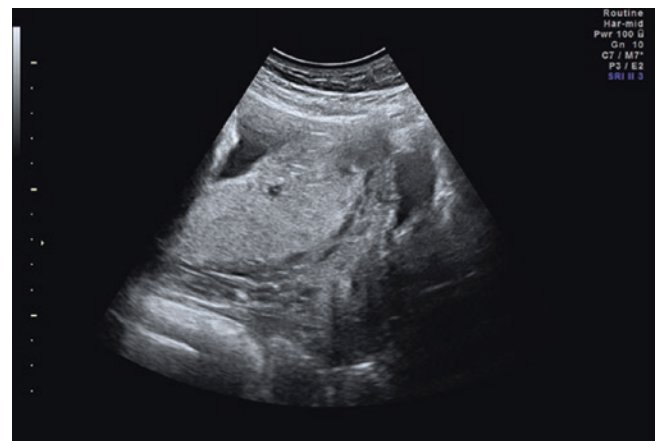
Major placenta previa at transabdominal ultrasound
